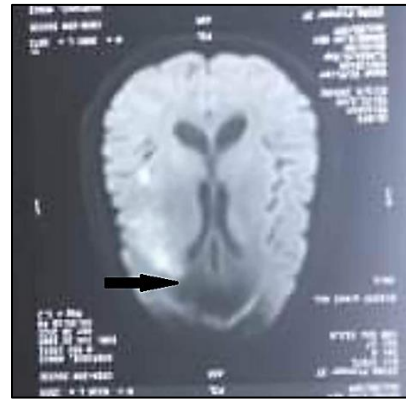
MRI slide showing left superficial middle cerebral ischemic stroke
